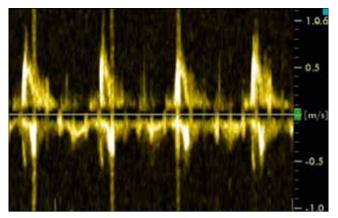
Transthoracic echocardiography. Transmitral pulse wave. Restrictive mitral flow
